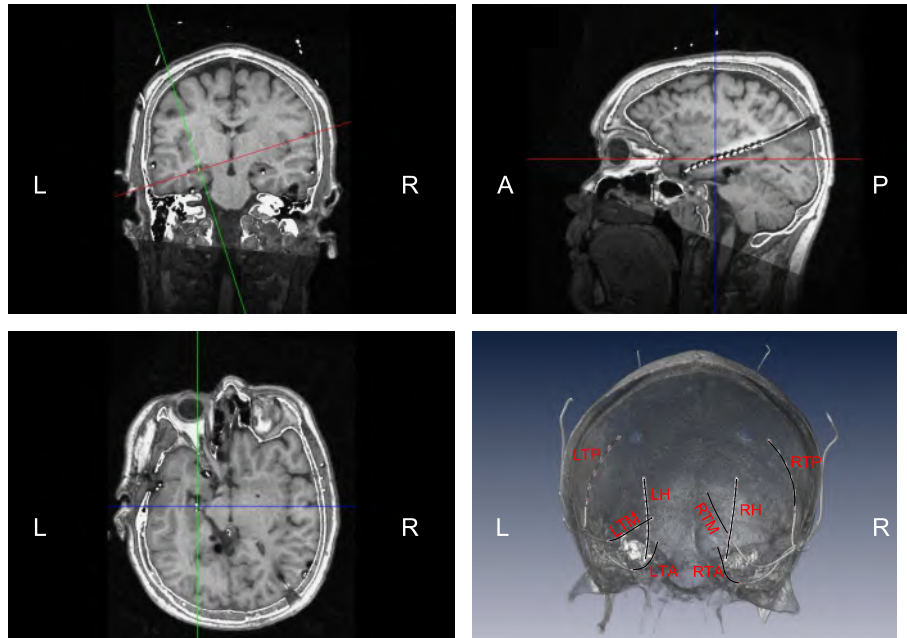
A CT image merged with a MR image showing the location of the intracranial electrodes. A rendering of the electrode positions is also shown in the right lower image for visualizing the strip and depth electrodes. Four subdural strips with 4 contact points are placed on the left and right temporobasal area (left anterior: LTA1-4, left posterior: LTM1-4, right anterior: RTA1-4 and right posterior: RTM1-4), two subdural strip with 6 contact points monitor the left and right temporolateral area (left: LTP1-6 and right: RTP1-6) and two amygdalo-occipital depth electrodes with each 12 contact points, respectively LH1-12 and RH1-12, monitor the electrical activity of the left and right amygdala and hippocampus. The intersection of the lines denotes the position of LH5.
